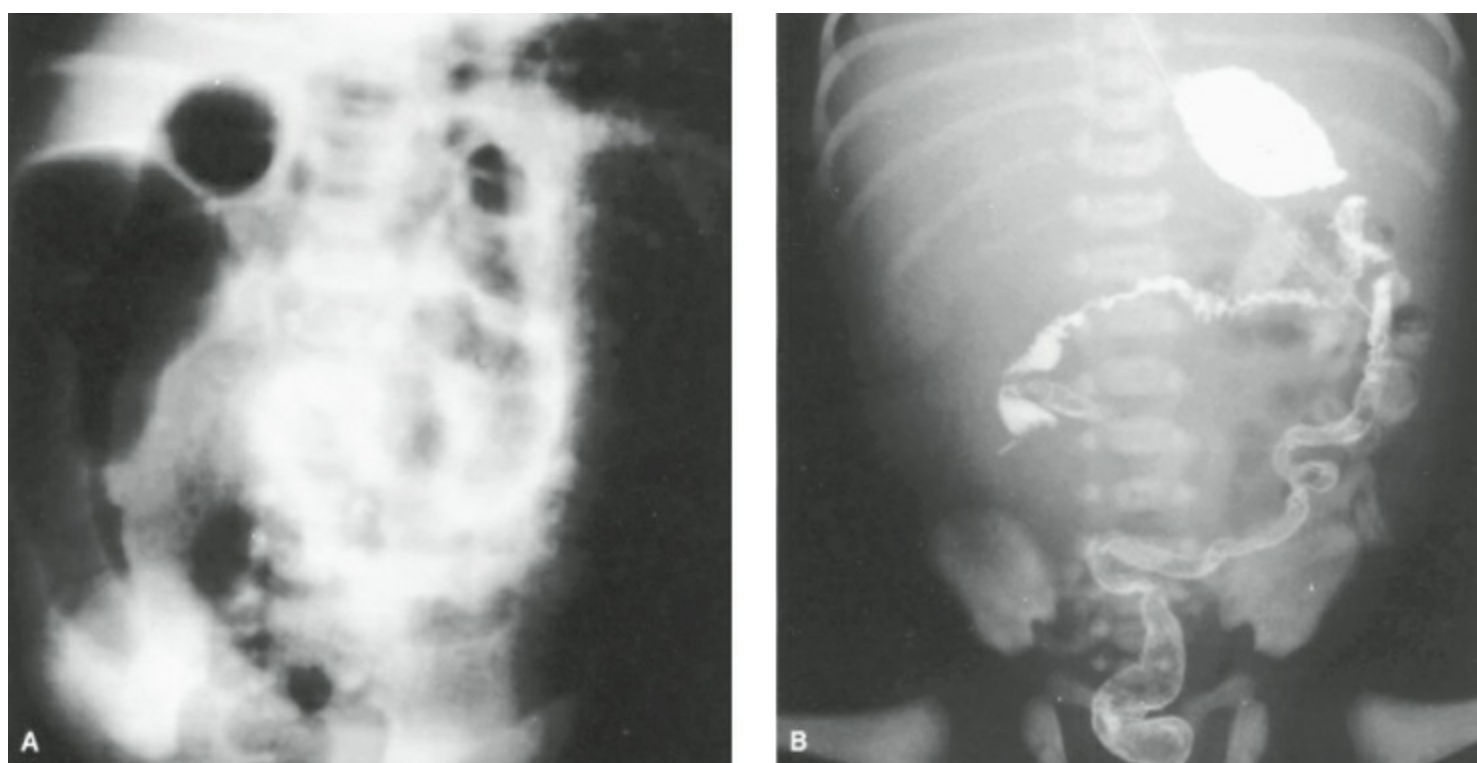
A: Plain radiograph of neonate with meconium ileus. B: Contrast enema in an infant with meconium ileus demonstrating an unused but intrinsically normal microcolon.
